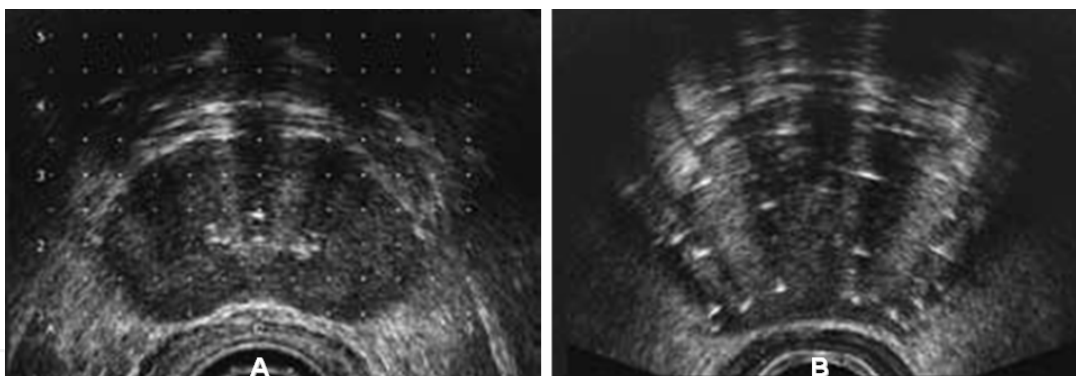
Prostate brachytherapy. (A) Transrectal ultrasound set-up: transverse image of the prostate with 5mm template overlay. (B) Transverse image of the prostate after seed implant (echogenic areas)
